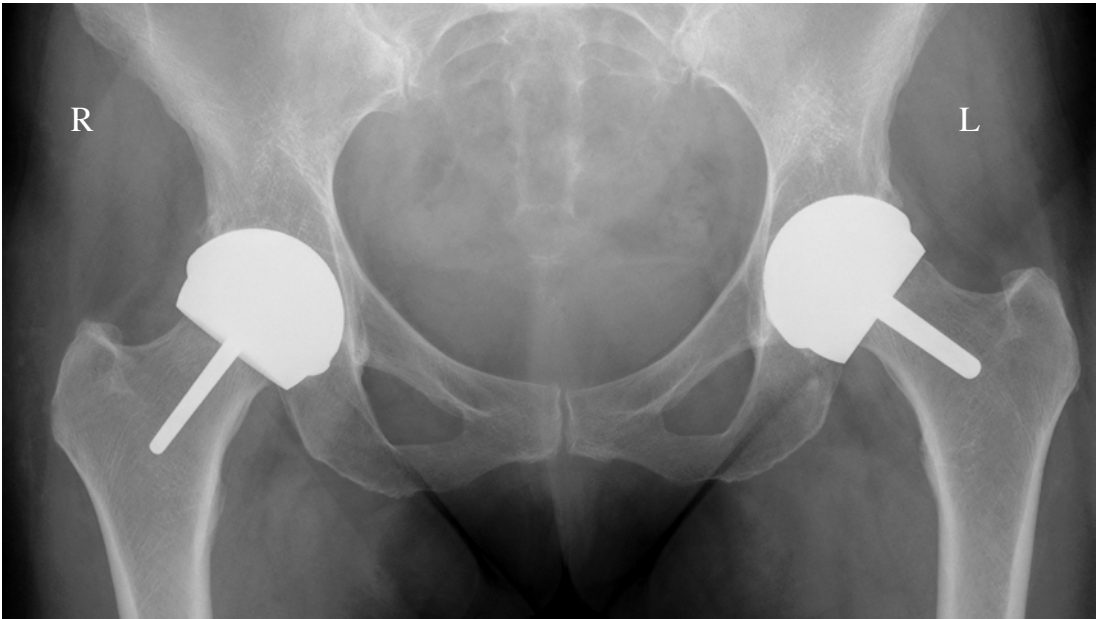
Pelvis x-ray showing a Conserve Plus on the right hip, a BHR implant at the left.
